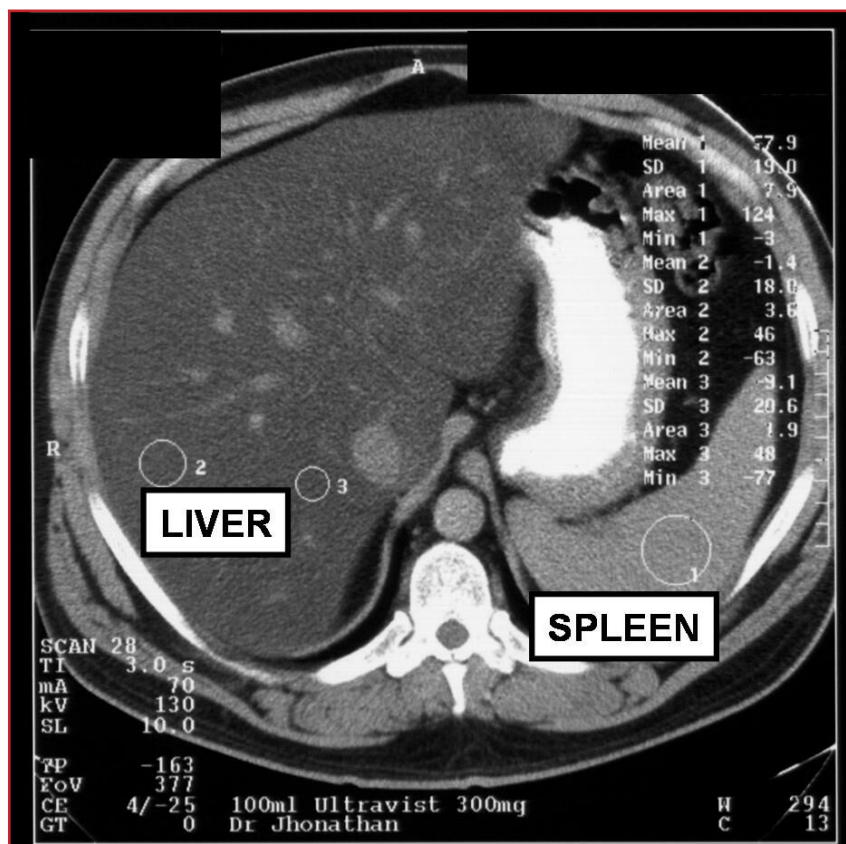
CT scan of a patient with NASH. The liver is enlarged. In normal situations the liver and spleen are of the same density. Here the density of the liver (left) is clearly attenuated compared with the spleen (right).
